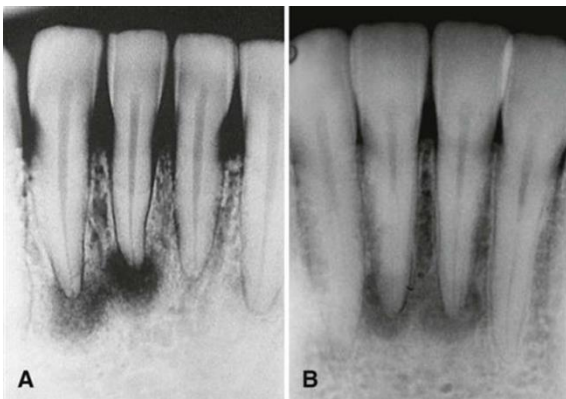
Large periapical radiolucency associated with tooth.
